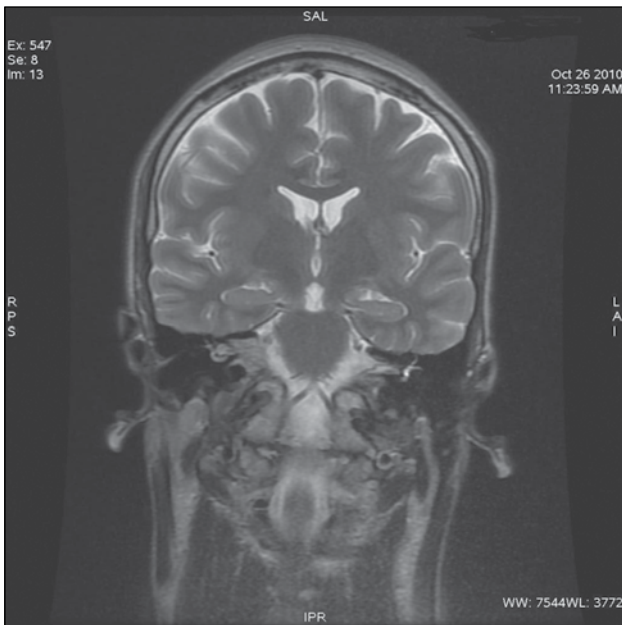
MRI: left-side hippocampal gliosis with no atrophy
